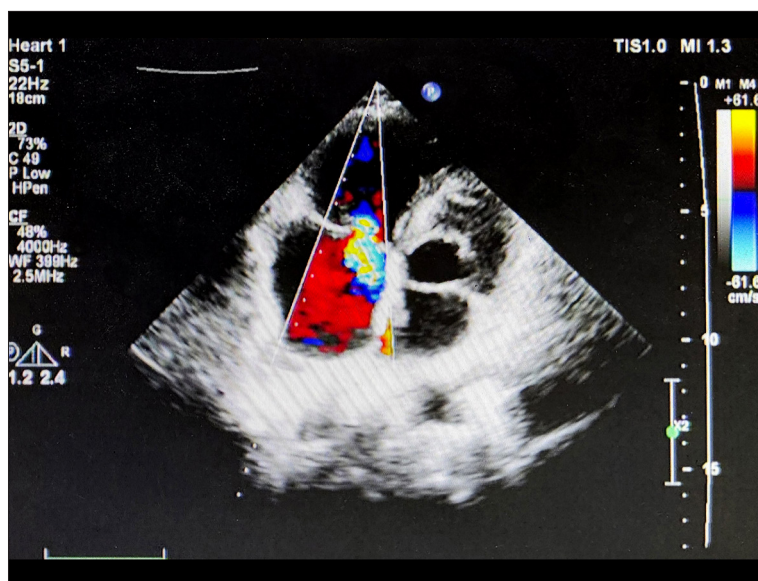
Transthoracic echocardiography (apical four-chamber view with color Doppler) demonstrating right heart enlargement and moderate-to-severe tricuspid regurgitation. The mosaic color jet indicates the regurgitant flow across the tricuspid valve.
